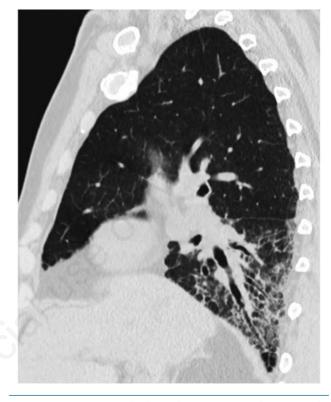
Our patient high-resolution computed tomography (HRCT) at diagnosis. Typical UIP HRCT pattern shown on sagittal view. Honeycombing, reticulation and peripheral bronchiectasis with basal and subpleural predominance are present.
